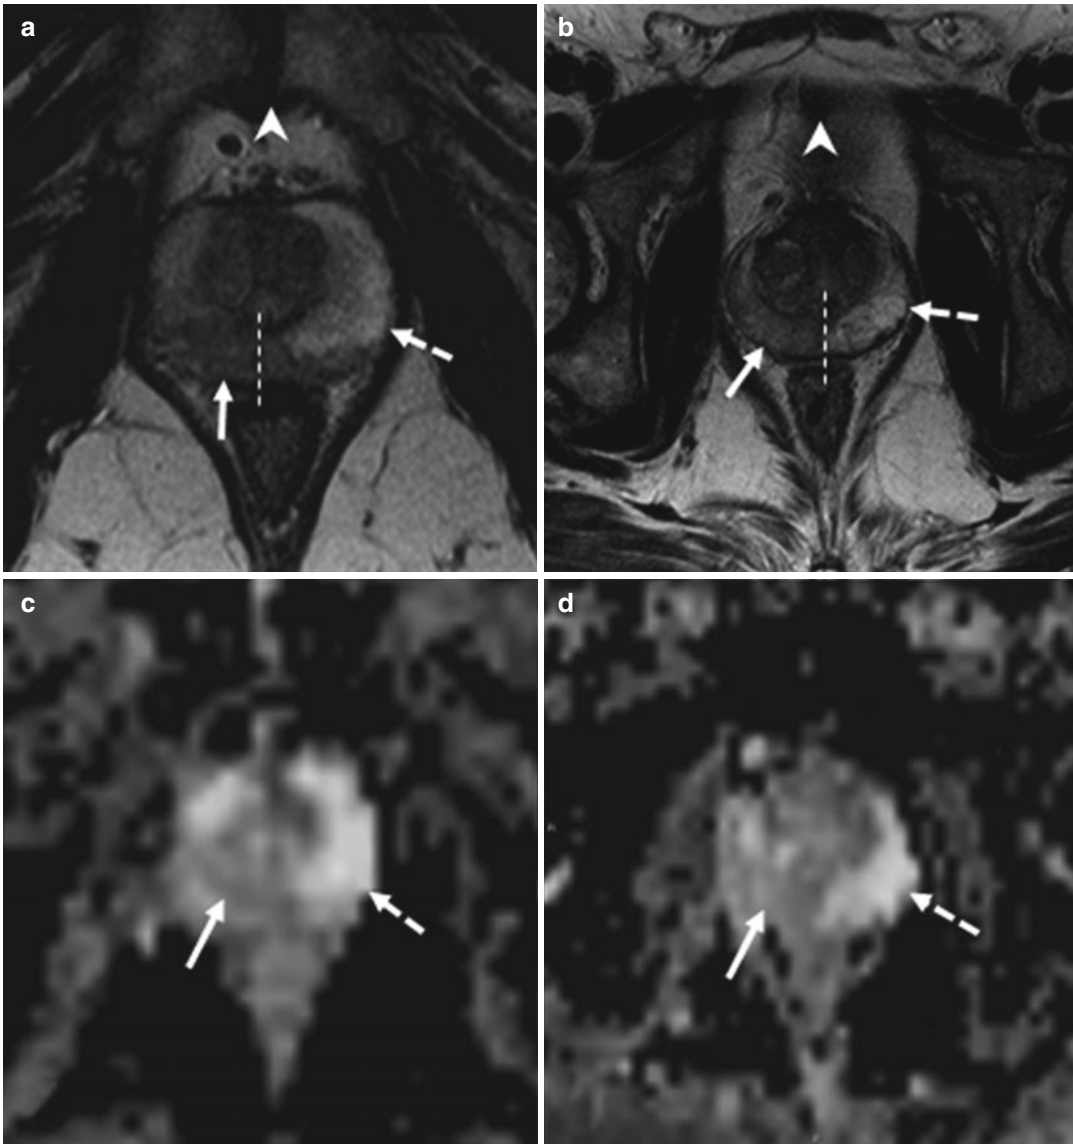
(a–f) 58 years old, PSA 6.7 ng/ml, Gleason 7 (3+4). (a, c, e) axial sections at the lower third; on a, the symphysis pubis can be identified (*arrowhead* in a). (b, d, f) axial sections at the middle third, just above the symphysis pubis, that are not identifiable (*arrowhead* in b). (a, b) T2-weighted images (TR: 3600; TE: 100); (c, d) ADC images; (e, f) post-contrastographic images (TR: 12; TE: 5,8). On T2-weighted sequence at the lower third (a), a hypointense area (*arrow*) can be documented at the right lobe of the prostate, with extension to the left lobe (the *dashed line* represents the limit of the two lobe). On ADC
